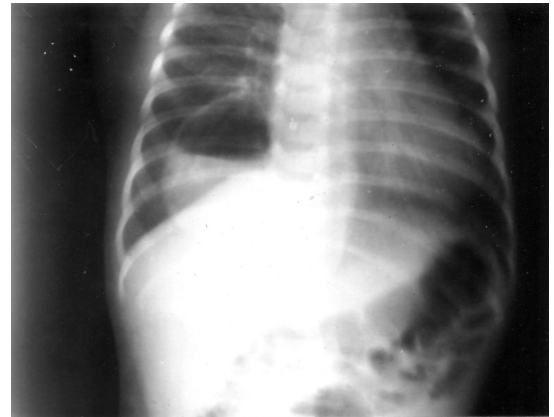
X-ray Chest: Features suggestive of consolidation right lower lobe
